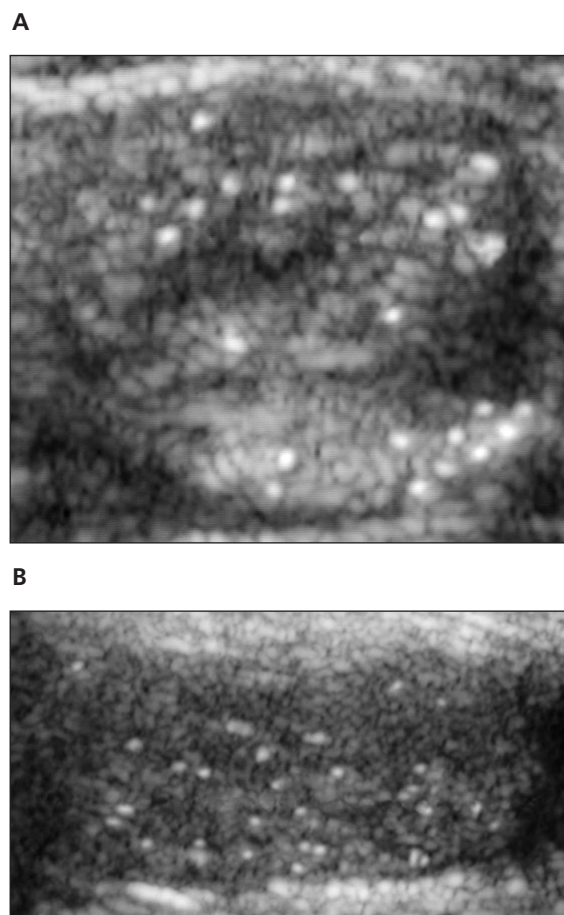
A, Transverse sonogram of the left testis showing more than 5 microliths per sonographic plane. The microliths are without acoustic shadowing and are scattered diffusely throughout the testicular parenchyma. B, Longitudinal sonogram of the left testis showing the same findings as in A.
